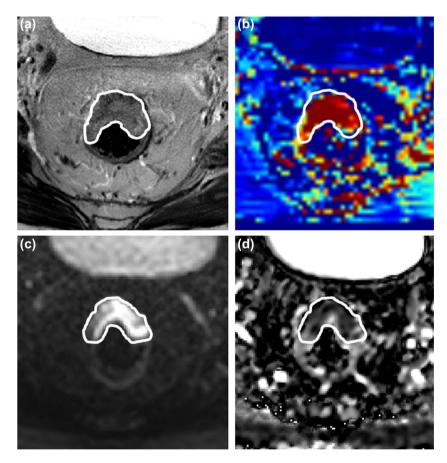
cT3N2 rectal adenocarcinoma in a 60-year-old male patient. T2-weighted imaging (a), Ktrans map (b), b800 image (c) and apparent diffusion coefficient map (d).
